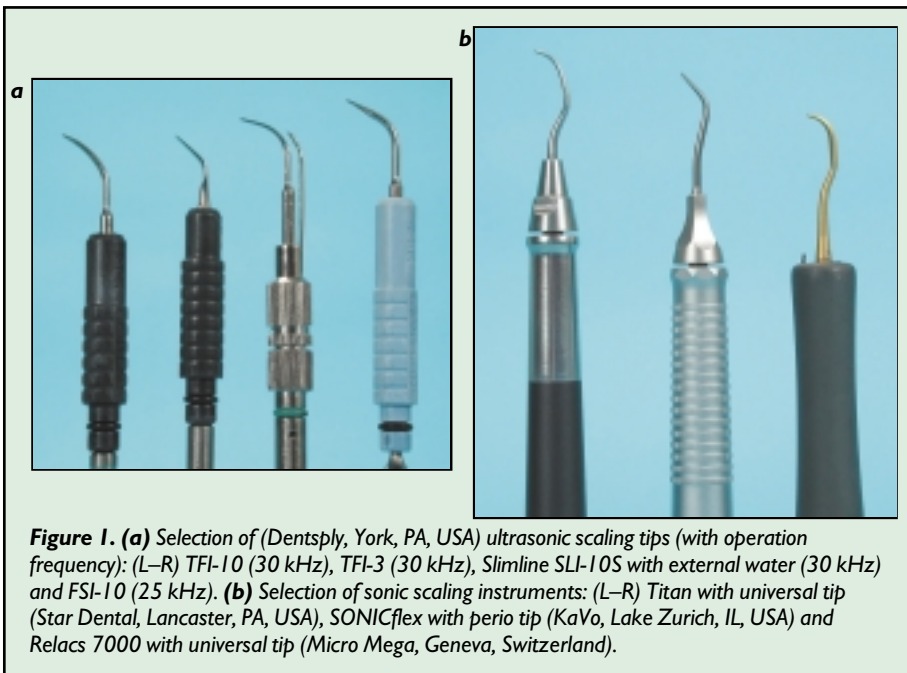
(a) Selection of (Dentsply, York, PA, USA) ultrasonic scaling tips (with operation frequency): (L–R) TFI-10 (30 kHz), TFI-3 (30 kHz), Slimline SLI-10S with external water (30 kHz) and FSI-10 (25 kHz). (b) Selection of sonic scaling instruments: (L–R) Titan with universal tip (Star Dental, Lancaster, PA, USA), SONICflex with perio tip (KaVo, Lake Zurich, IL, USA) and Relacs 7000 with universal tip (Micro Mega, Geneva, Switzerland).
